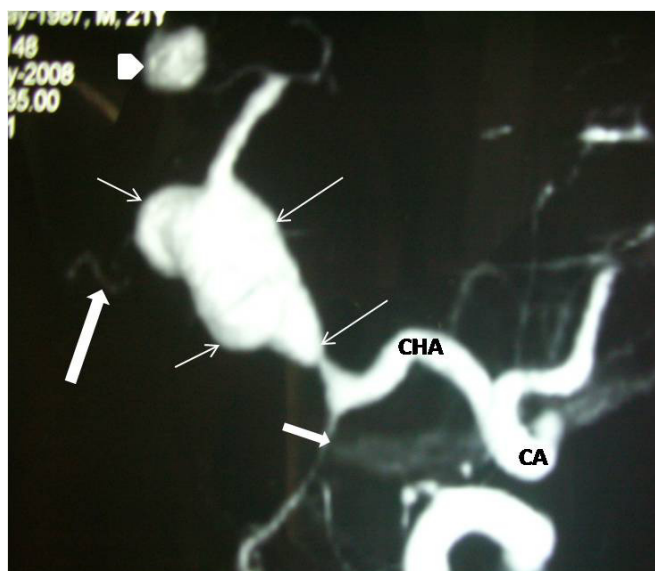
CT angiography shows the large fusiform aneurysm involving proper hepatic artery extending in to the root of right hepatic artery (mapped by thin arrows). Another aneurysm is seen in relation to a branch of left hepatic artery (arrowhead). The attenuated right hepatic artery is seen distal to the aneurysm (long black arrow). Short black arrow is highlighting the gastroduodenal artery. CHA: common hepatic artery; CA: Celiac axis.
